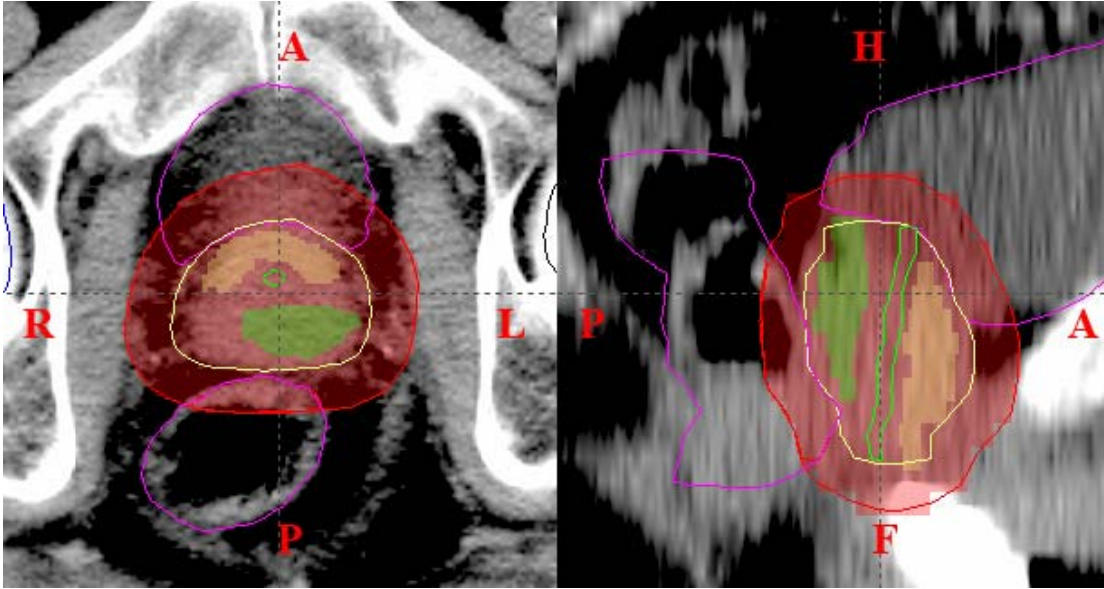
Transversal (left) and sagittal (right) view of structure contours in CT image (patient #1). Green contour shows urethra. Yellow contour in the center is CTV with chronic hypoxia region (yellow segment) and acute hypoxia region (green segment).
